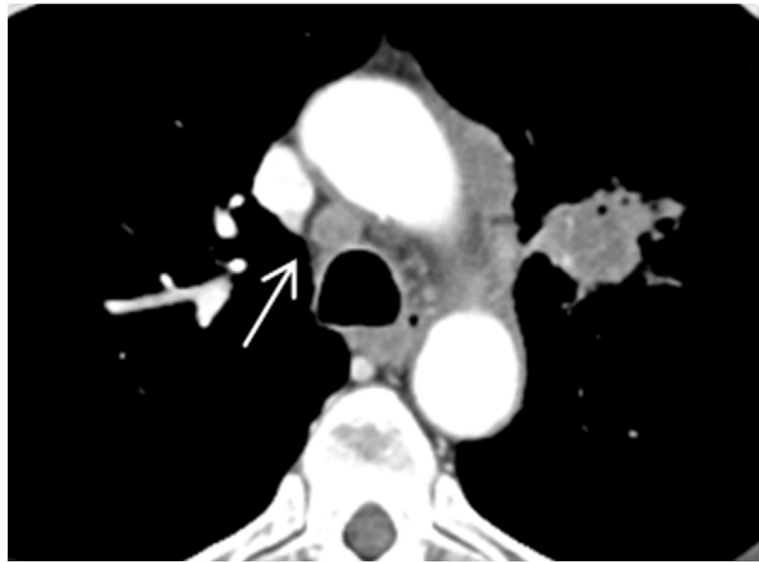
Axial CT image revealed a rounded lymph node on 4R (arrow). Long-axis diameter is 1.13 cm, and short-axis diameter is 0.97 cm. Axial S/L ratio is 0.86. The pathology result is non-small cell lung cancer.
